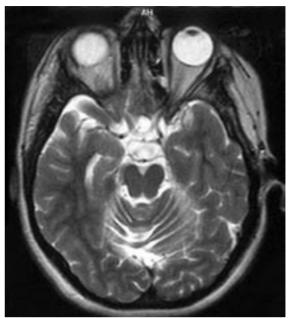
Magnetic resonance coronal T2-weighted image of Patient 1 showing cerebral and cerebellar atrophy and cerebellar vermis hypoplasia.
